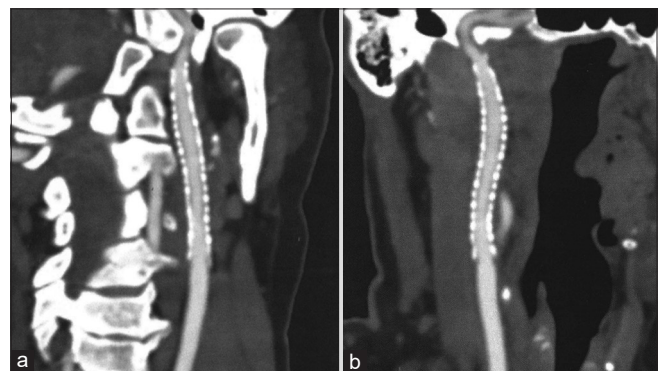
(a) Follow-up computed tomography angiogram, 12 months after stenting. The image showing the right cervical internal carotid artery in the sagittal plane. (b) Follow-up computed tomography angiogram, 12 months after stenting. The image showing the right cervical internal carotid artery in the coronal plane
